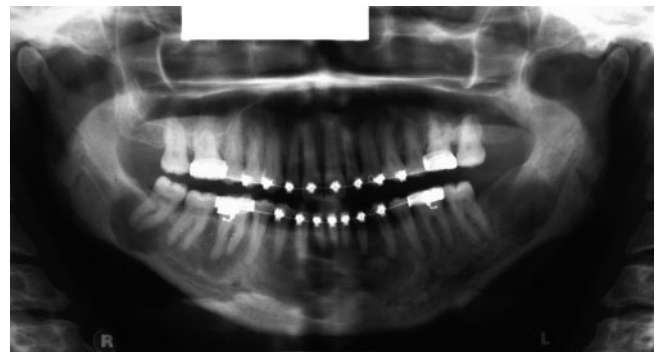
Mid-treatment orthopantomograph
